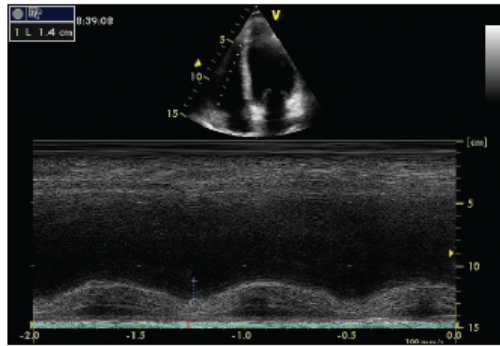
Right ventricle systolic dysfunction, estimated using tricuspid annular systolic plane excursion-method echocardiography
